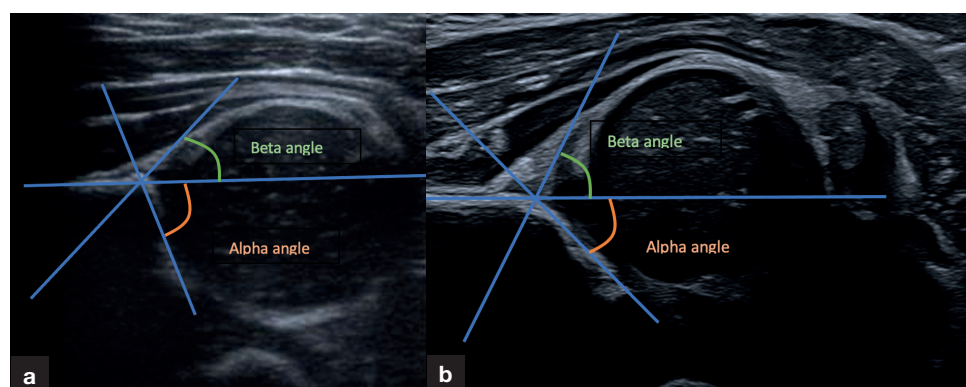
a. Ultrasound image of a normal Graf grade I hip showing an alpha angle of 68° and beta angle of 55° . b. Ultrasound image of an abnormal Graf grade II dysplastic hip showing a reduced alpha angle of 45° and increased beta angle of 70° .
